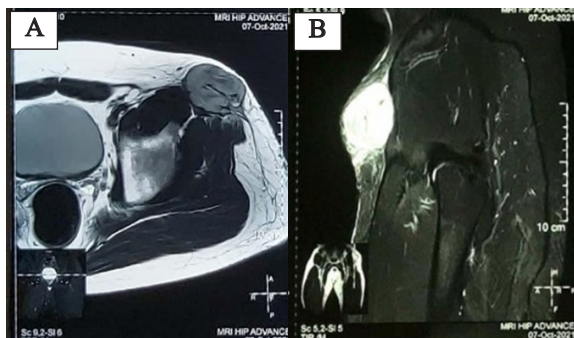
(A) Axial view of hip MRI before the third surgery & (B) Coronal view showed recidive mass at the surgical bed of the left proximal femur.
